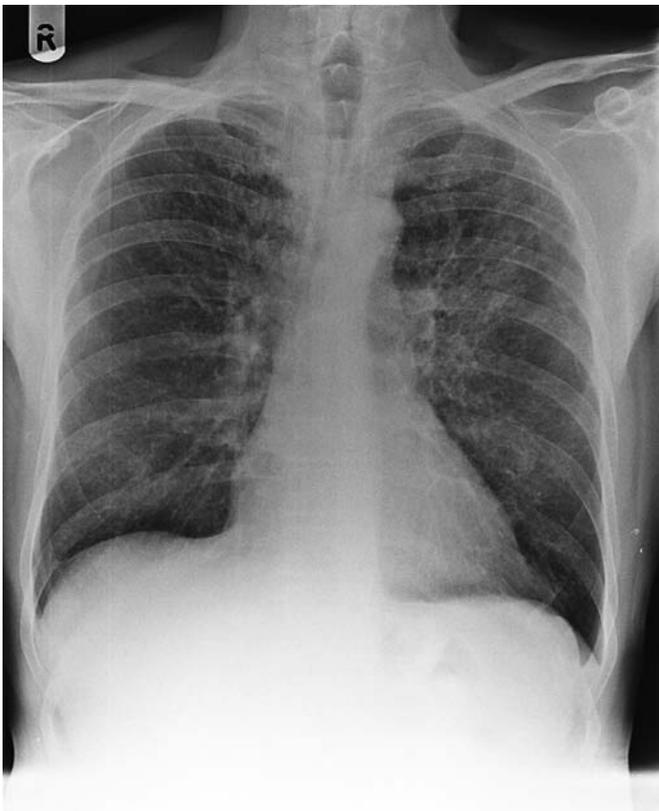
Chest radiograph at day 10 showing resolving pulmonary infiltrates.
